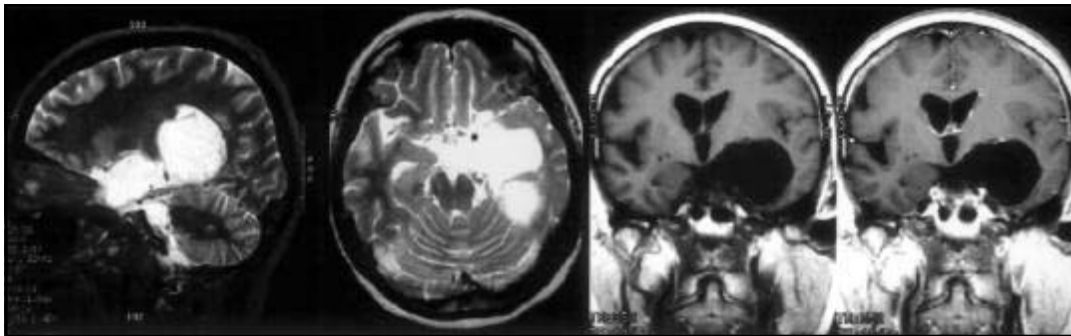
MRI Sagittal T2WI, Axial T2WI, Coronal T1WI pre- and postcontrast (Gd-DTPA): bulky cyst in the supra sellar cistern and in the left coroid fissure.
